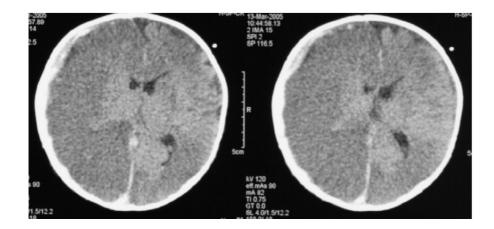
Patient #3. CT scan on admission shows widespread hypoxic/ ischaemic changes (low attenuating areas) in the bilateral cerebral parenchyma, with sparing of central grey matter structures. There is also a thin acute SDH on the right side
